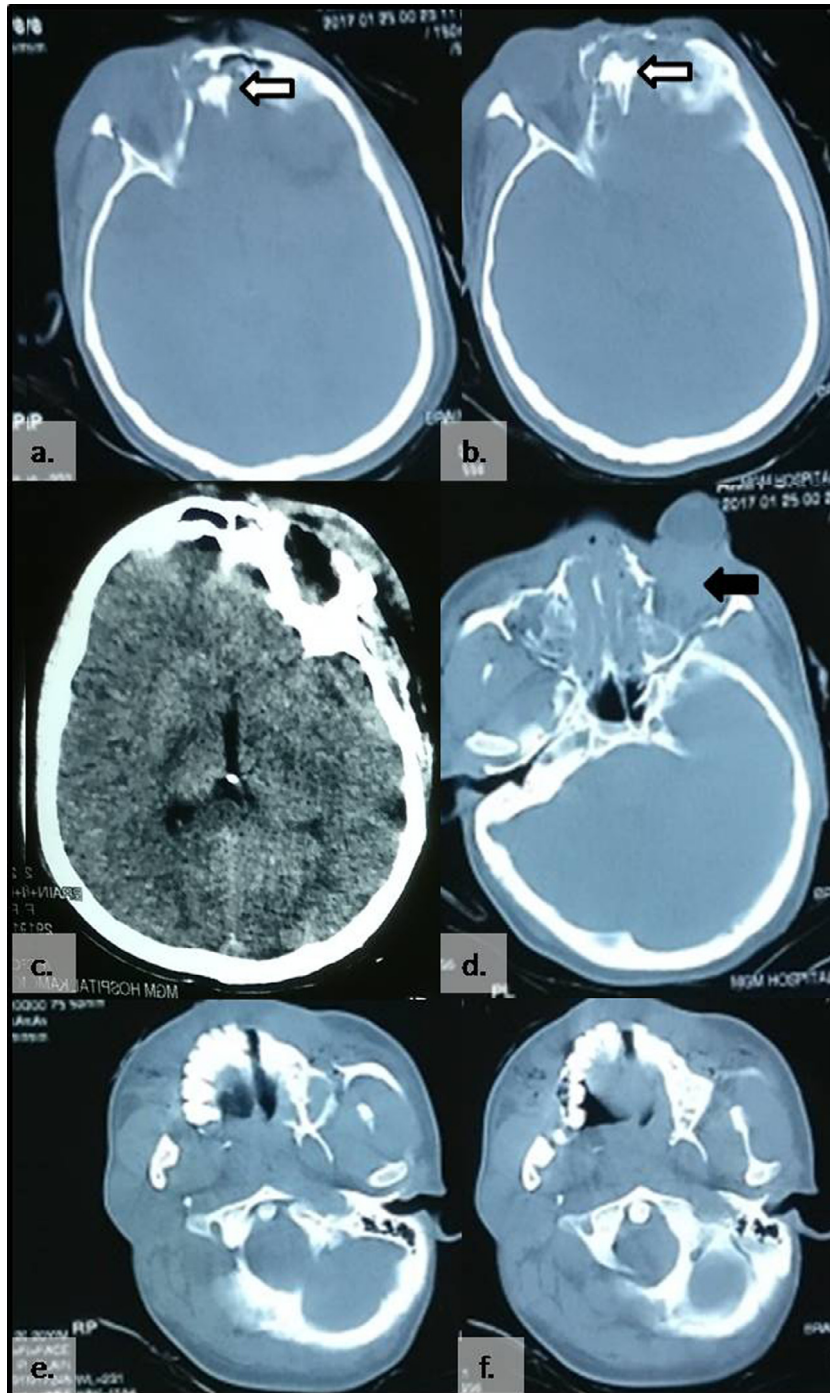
Computed Tomography (CT) Imaging (a, b) Fractured frontal bone piece impacted in brain parenchyma (White arrow). Right sided lateral wall of orbit fracture. (c) Blow in fracture of frontal bone at orbital roof. (d) Globe subluxation with retrobulbar hemorrhage (black arrow). (e, f) Palatal split and extensive mid facial fractures.
